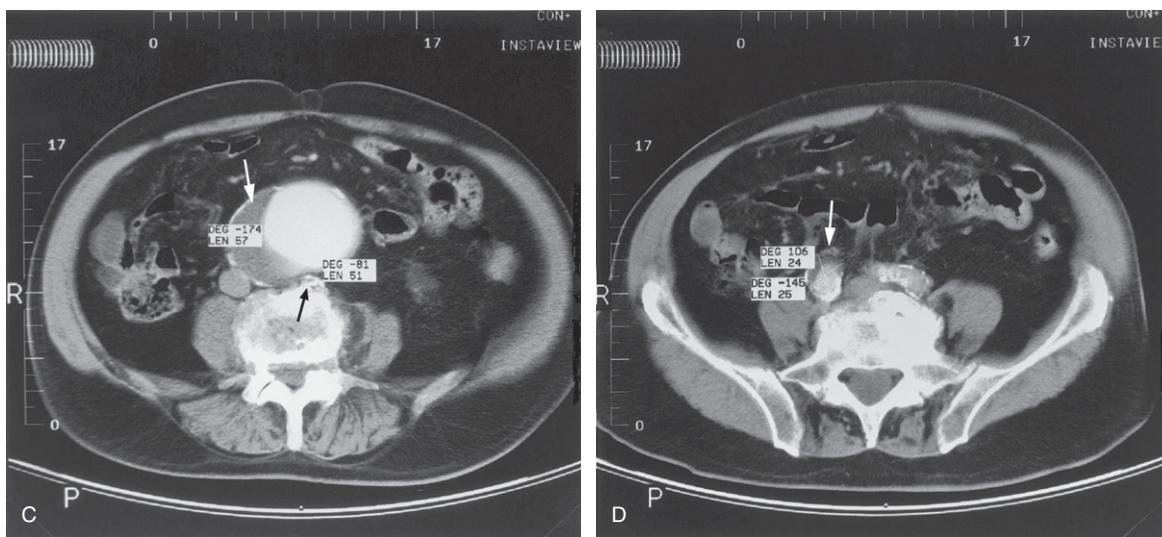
Cont'd (C and D) CT Axial image with contrast showing the large abdominal aortic aneurysm (8×6 cm) with the right lateral eccentric thrombus (white arrow). Note how the lumbar spondylosis (small black arrow) is indenting the aortic aneurysm posteriorly which could make the wall of the aneurysm vulnerable to bleeding. (D) Axial CT scan showing that the aneurysm involves the origin of the right common iliac artery which has a maximal diameter of 2.4×2.5 cm (arrow).
